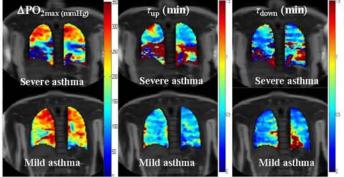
The OE-MRI parameter maps of a severe asthmatic participant (F, 19yrs, FEV₁ % Pred norm. =63.5%) and a mild asthmatic participant (F, 19yrs, FEV₁ % Pred norm.=99.0%).
